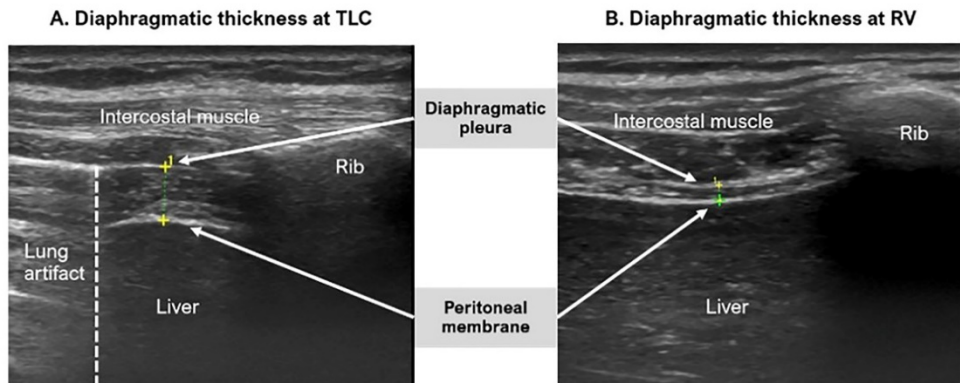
Diaphragmatic ultrasound showing three layers of diaphragm and diaphragmatic thickness at total lung capacity (TLC) in (a) and residual volume (RV) in (b).
